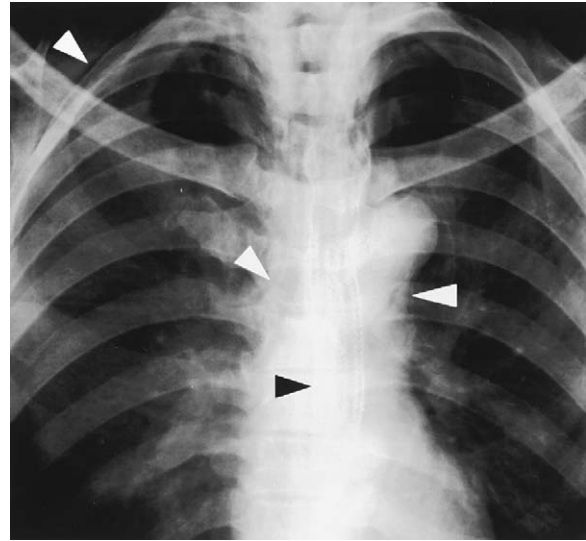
Chest radiograph following immediate stent placement for iatrogenic perforation of a midesophageal carcinoma. Air is present in subcutaneous tissues and adjacent to the trachea and aorta (*white arrowheads*). An expandable stent has been placed across the perforated tumor (*black arrowhead*).
